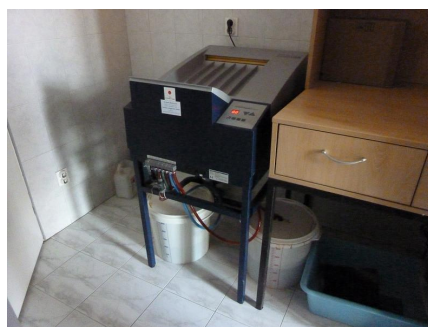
Film X-ray Development Machine with Waste Fluid Container (Zenica, FBiH)
